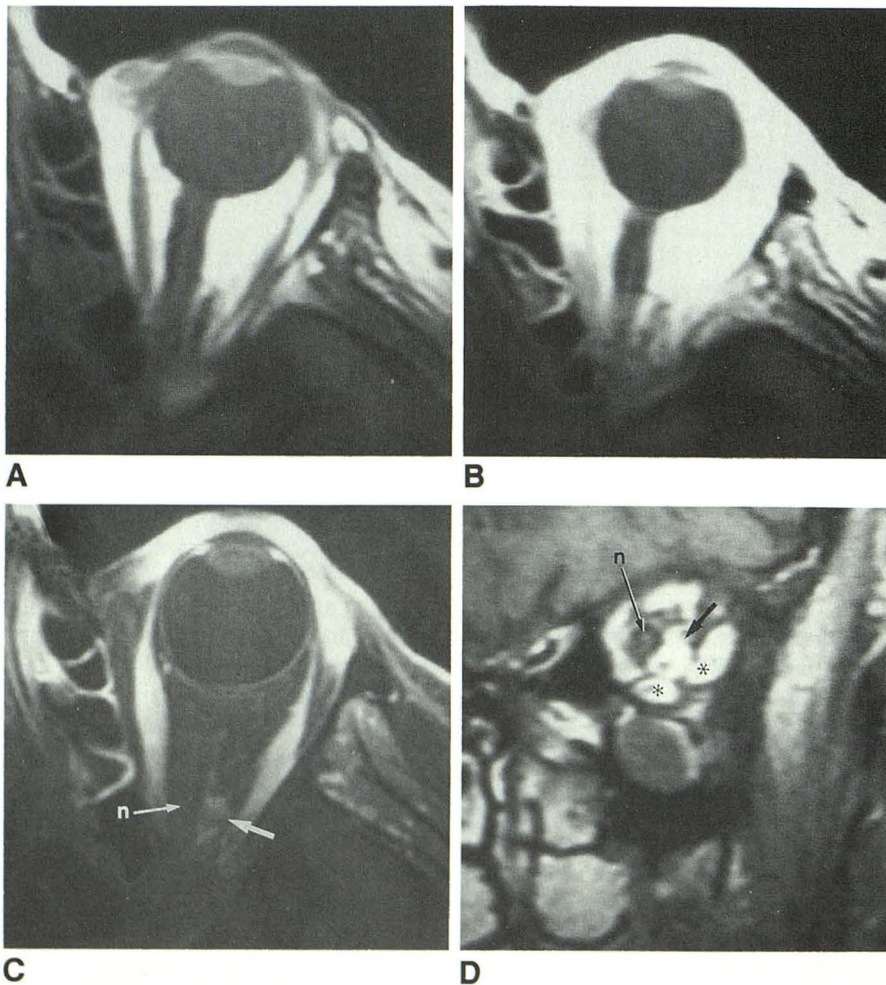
A–D, Axial (A–C) and coronal (D) T1-weighted spin-echo MR images of a small optic nerve sheath meningioma before IV injection of gadopentetate dimeglumine (A), after contrast administration (B), and with fat suppression after contrast administration (C and D). The lesion could be mistaken for normal vessels in A or B, but in C enhancing lesion (arrow) is clearly seen lateral to optic nerve (n), and in D it is seen as eccentric lesion (arrow) inferolateral to optic nerve in coronal plane. Lesion appears virtually isointense with extraocular muscles (asterisks in D). Fundoscopic examination and CT findings were most consistent with meningioma. (Case courtesy of Drs. Richard E. Appen and Joel Weinstein.)
